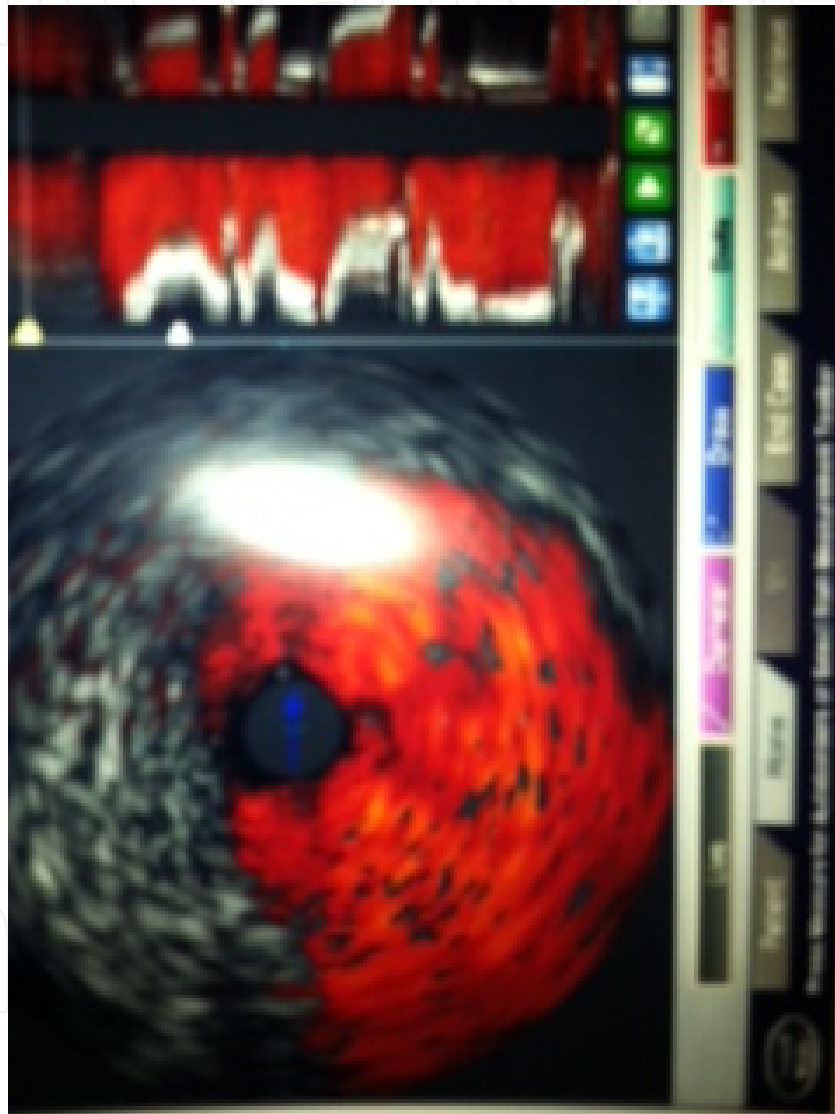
True aneurysm from 4 to 6O'clock position on intravascular ultrasound
